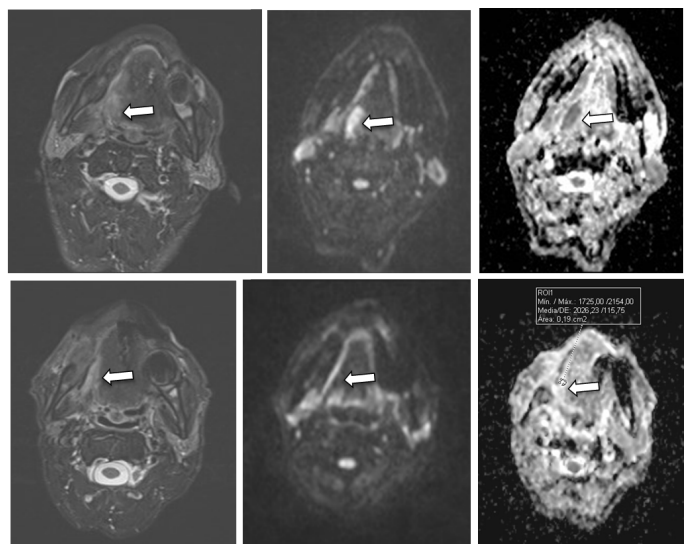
Oropharyngeal carcinoma. Same patient from Fig. 14, imaging after treatment (chemotherapy and radiation therapy). A. There is a significant decrease in the size of the focal area of abnormal signal intensity in the base of the tongue and right tonsil (arrow) in axial T2-WI. B. This area is no longer hyperintense on DWI B  $1000 \text{ sec}/\text{mm}^2$  (arrow). C. On ADC map it shows high signal intensity ( $2.02 \times 10^{-3} \text{ mm}^2/\text{sec}$ ) (arrow), i.e., there is no longer restriction of diffusion. A partial remission (partial response to the treatment) in MRI involves not only morphological improvement (T1-WI, T2-WI) but also complete or partial resolution of restricted diffusion in lesions with this feature.
